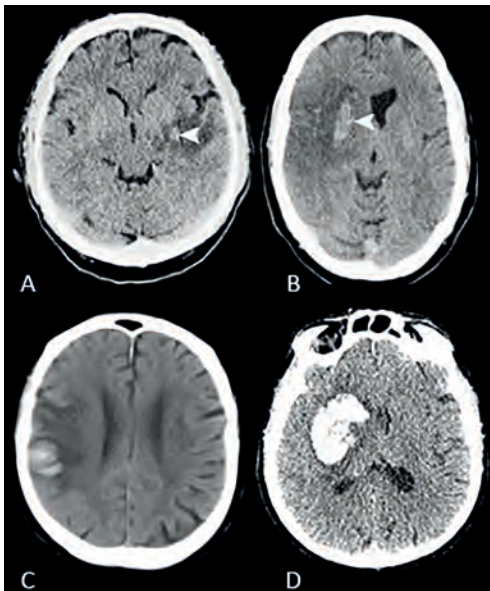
Non-contrast CT images of all hemorrhagic transformation subtypes. Hyperdense areas as pointed by the arrows indicate hemorrhagic transformation. A: hemorrhagic infarction type 1, B: hemorrhagic infarction type 2, C: parenchymal hematoma type 1, D: parenchymal hematoma type 2.
